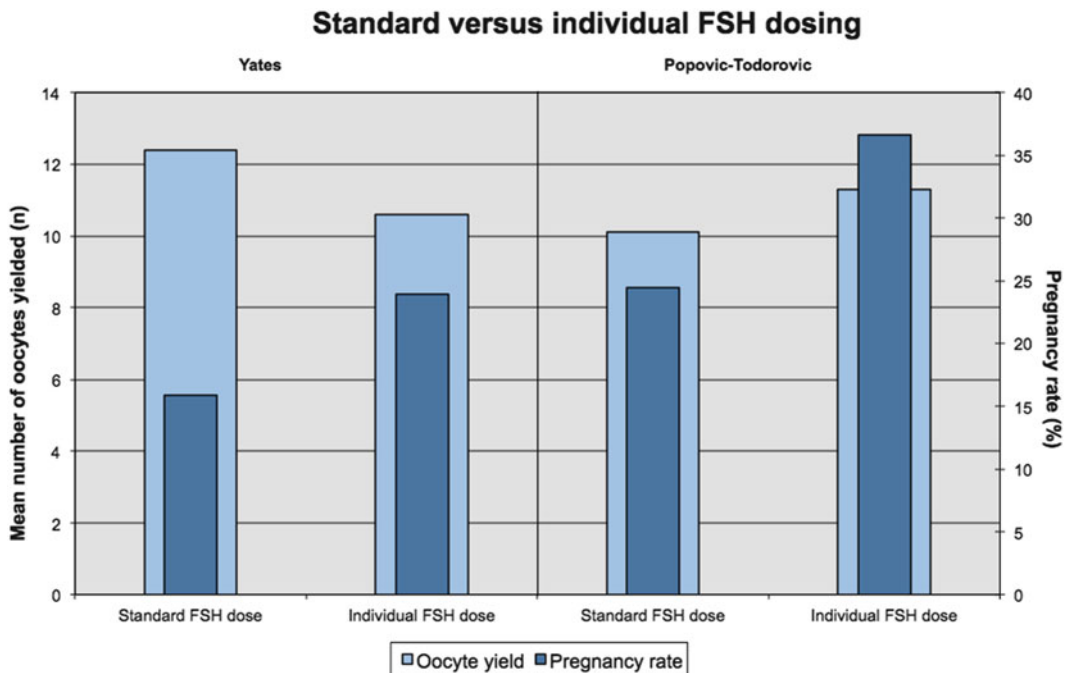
IVF outcome in standard versus individualised FSH dosing protocols. Yates et al. [103] used an AMH-tailored approach, in a non-randomised historical control group design. Popovic-Todorovic et al. [54] used an algorithm based on AFC, total ovarian volume, total Doppler score, age and smoking habits in a RCT design. The IVF outcome is represented by the mean number of oocytes yielded and ongoing pregnancy rate (Popovic-Todorovic
